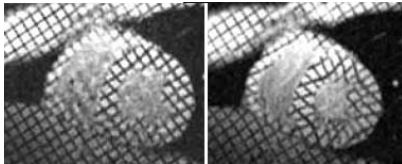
Cine tagged-MRI of the heart
